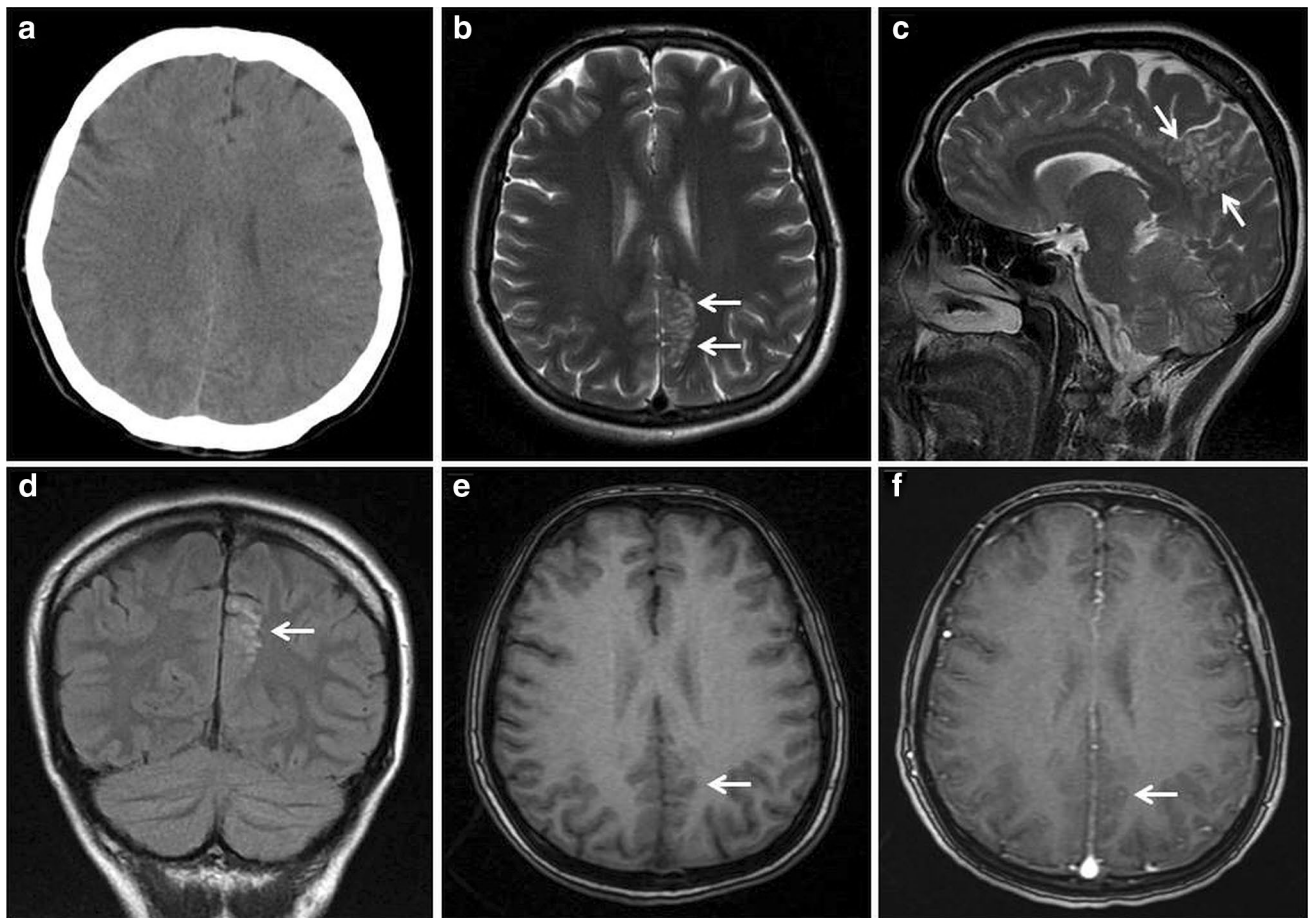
CT and MR images of a 27-year-old female patient with headache complaints. a The mass cannot be clearly distinguished on the CT examination. b Axial and c clustering multinodular lesion located in subcortical–juxtacortical area of left precuneus is seen on sagittal
